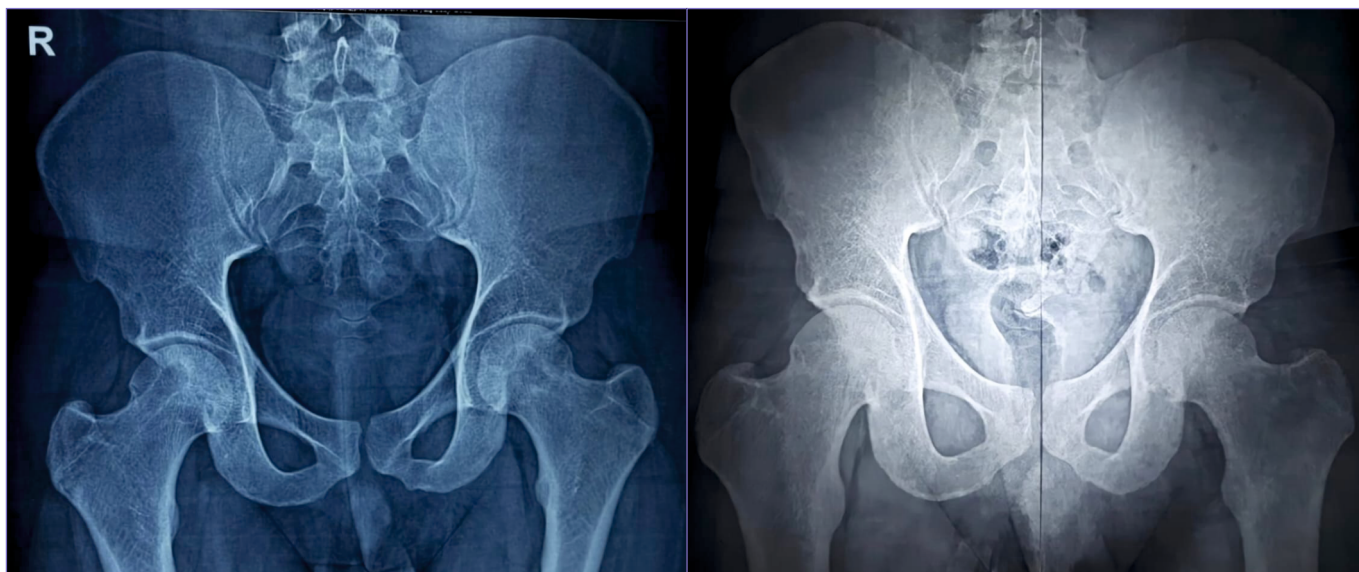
Pre-Op and Post-Op X-ray images before and after OSSGROW[®] cell therapy.
